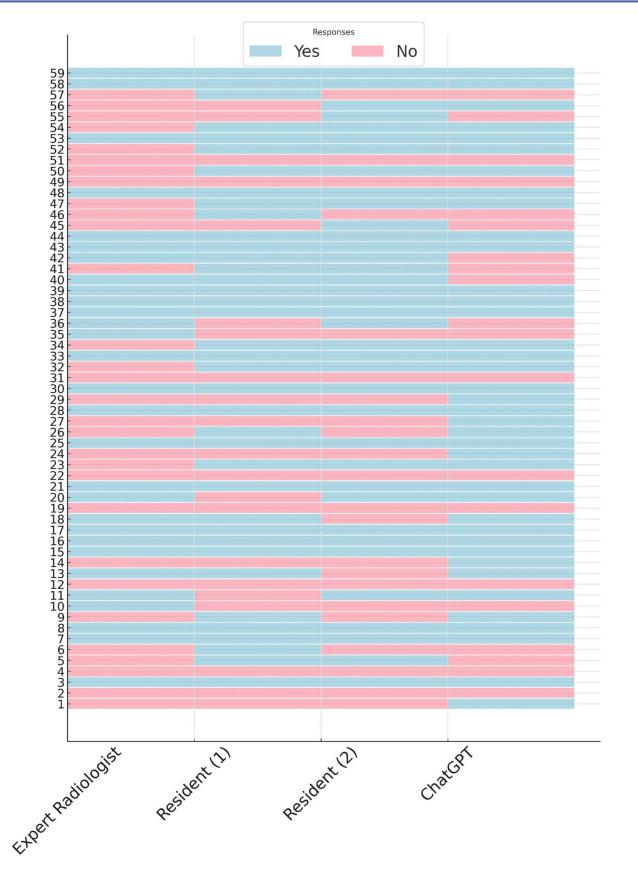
Expert radiologist's decision (gold standard), residents' and ChatGPT's decision on the necessity of CT in each patient
